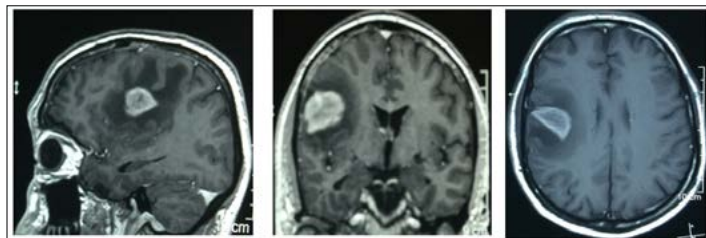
Contrast enhanced MRI scan brain 16 months after head injury
